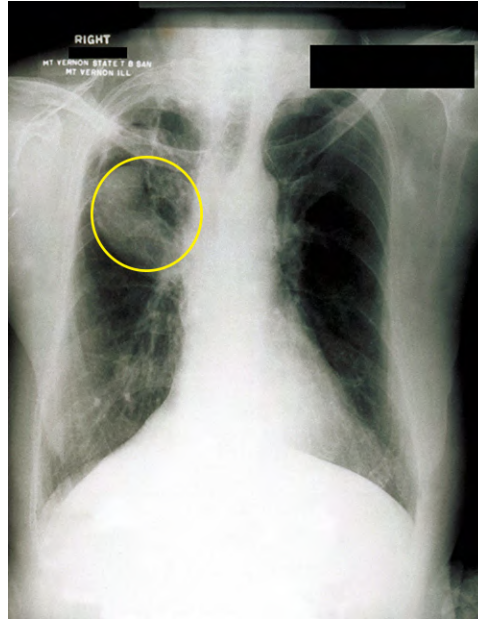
A fungal ball can be observed in the upper lobe of the right lung in this chest radiograph of a patient with aspergilloma. (credit: modification of work by Centers for Disease Control and Prevention)
